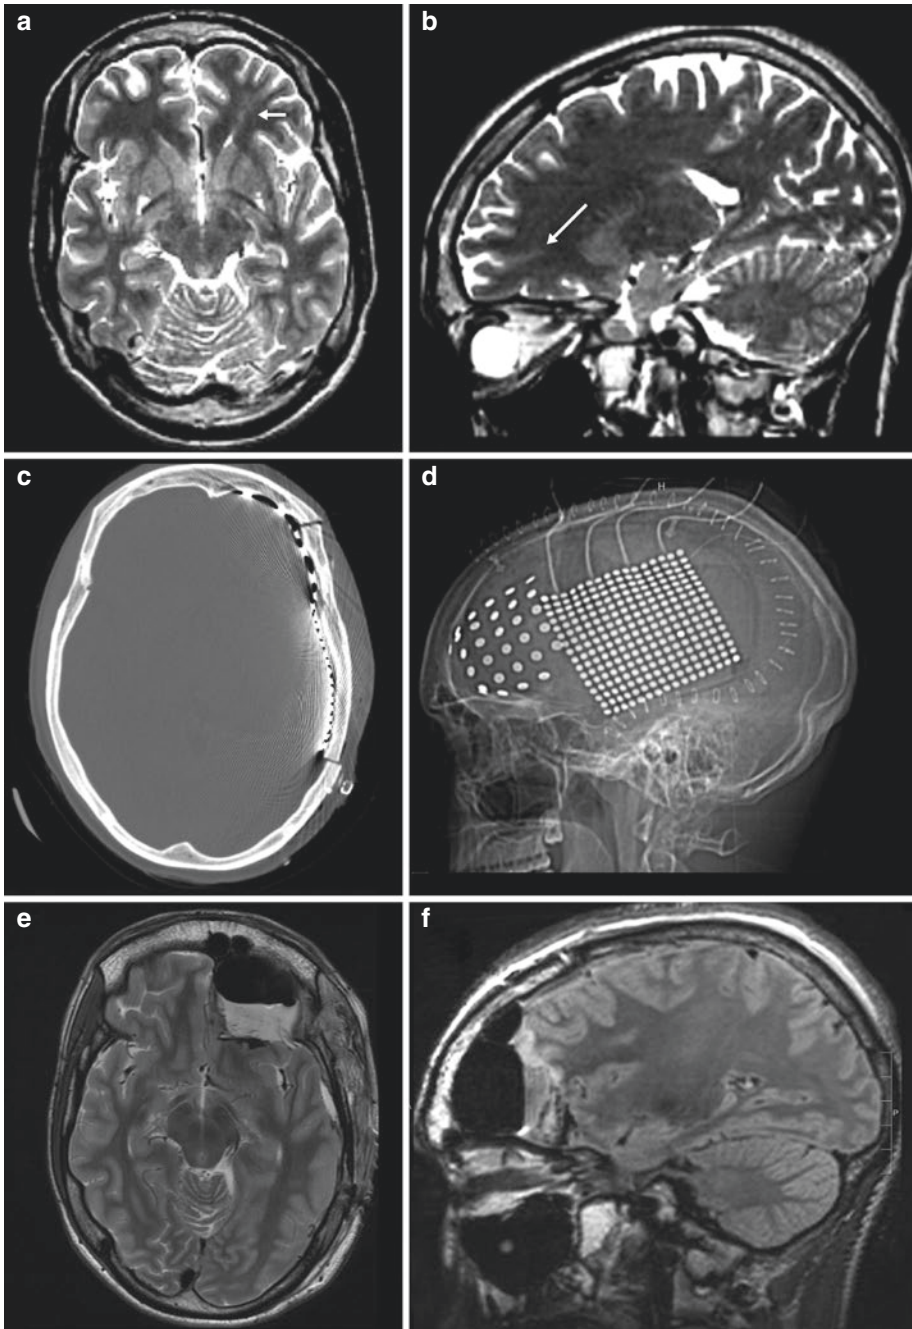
Frontal lobe epilepsy. This 18-year-old man had moderate developmental delay and multiple seizures daily. One type of seizures started with a “fuzzy feeling,” and the patient would curl into a ball, making grunting noises. His second type of seizures began with an overwhelming anxiety, sometimes a falling feeling, progressing to loud vocalizations and flinging of arms. Postictally he would be confused and aphasic for hours. (a, b) T2 MRI sequences showing a transmantle cortical dysplasia (arrows) in the left anterior inferior frontal gyrus, extending toward the frontal horn of the left lateral ventricle. (c)
